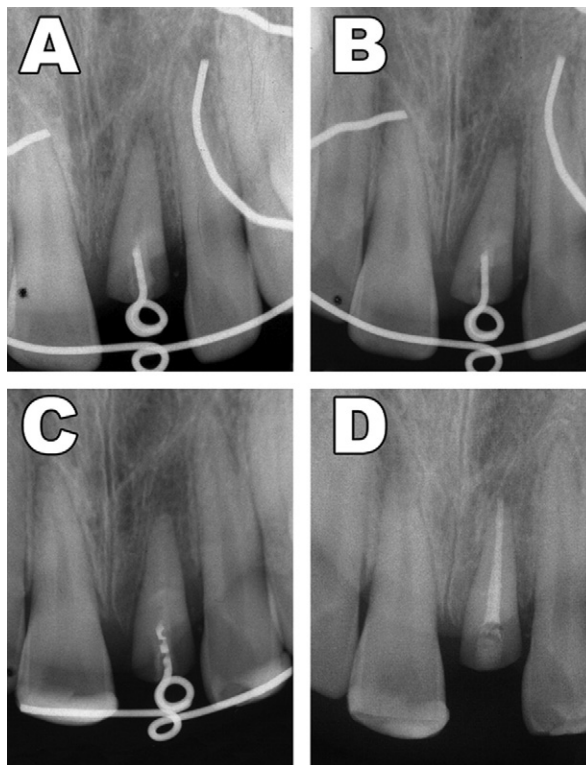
Position of the loop extension within the canal and advancement of the orthodontic extrusion as viewed radiographically. A, 1-month; B, 3-month; C, 5-month; and D, 6-month view showing extent of extrusion and final obturation of the root canal.
